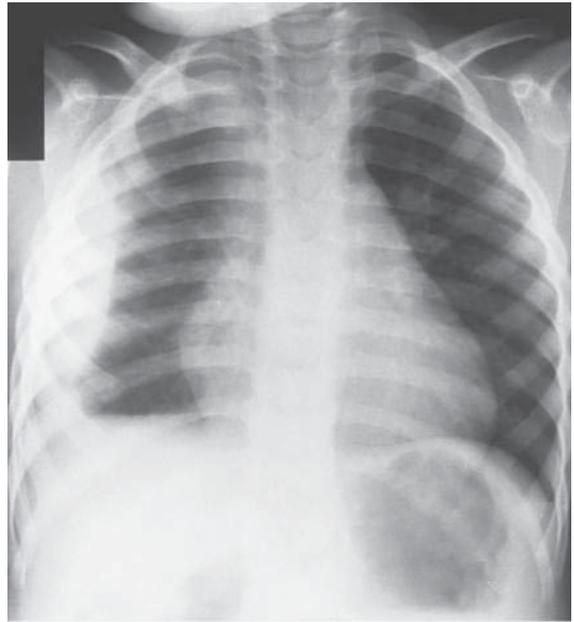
Pneumococcal empyema on the chest radiography of a 3 yr old child who has had upper respiratory symptoms and fever for 3 days. A pleural fluid collection can be seen on the right side. The patient had a positive pleural tap and blood culture result for pneumococci. The child recovered completely within 3 wk. (From Kuhn JP, Slovis TL, Haller JO (eds): *Caffrey's pediatric diagnostic imaging*, ed 10, Philadelphia, 2004, Mosby, p. 1002.)
